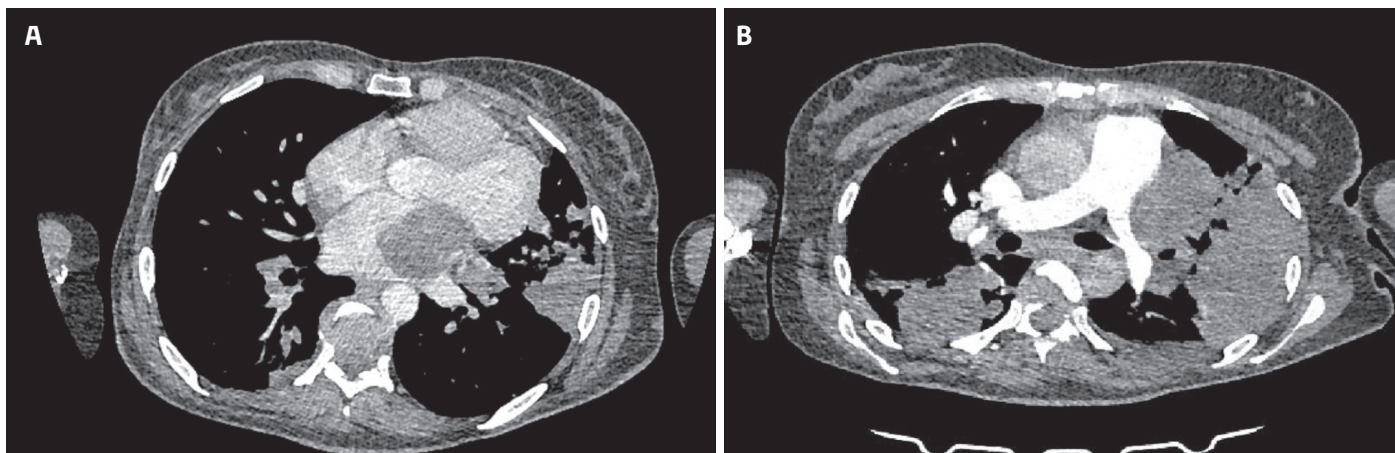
Thorax CT shows a large left atrial mass (A) and left main pulmonary artery was narrowed due to mass effect (B).
